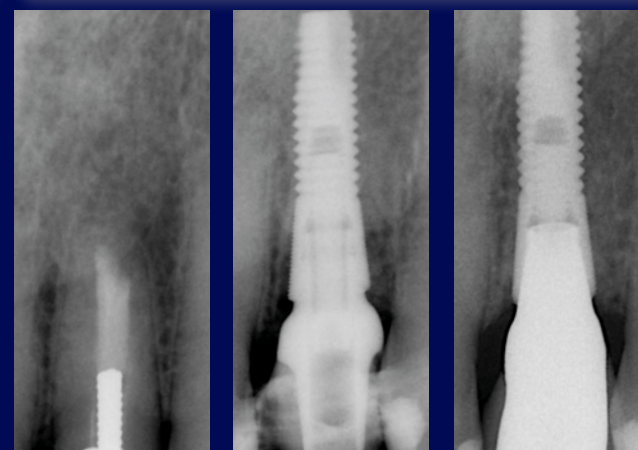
l & m: X-rays pre-op, at insertion and at 15 months.
